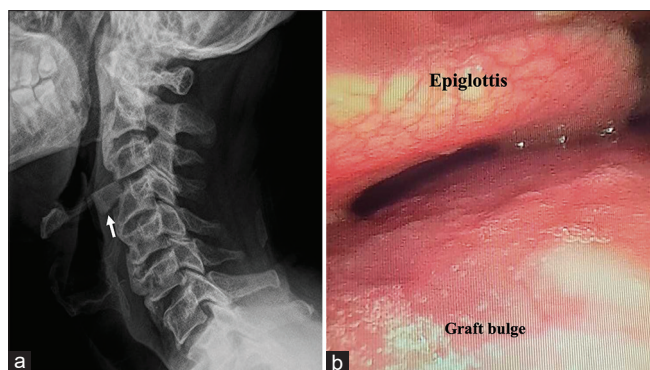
(a) Lateral neck X-ray showing anterior extrusion of the bone graft (arrow) and impingement of the hypopharynx. (b) Fiberoptic image showing narrowed space with the edematous epiglottis and posterior wall bulge due to graft extrusion
